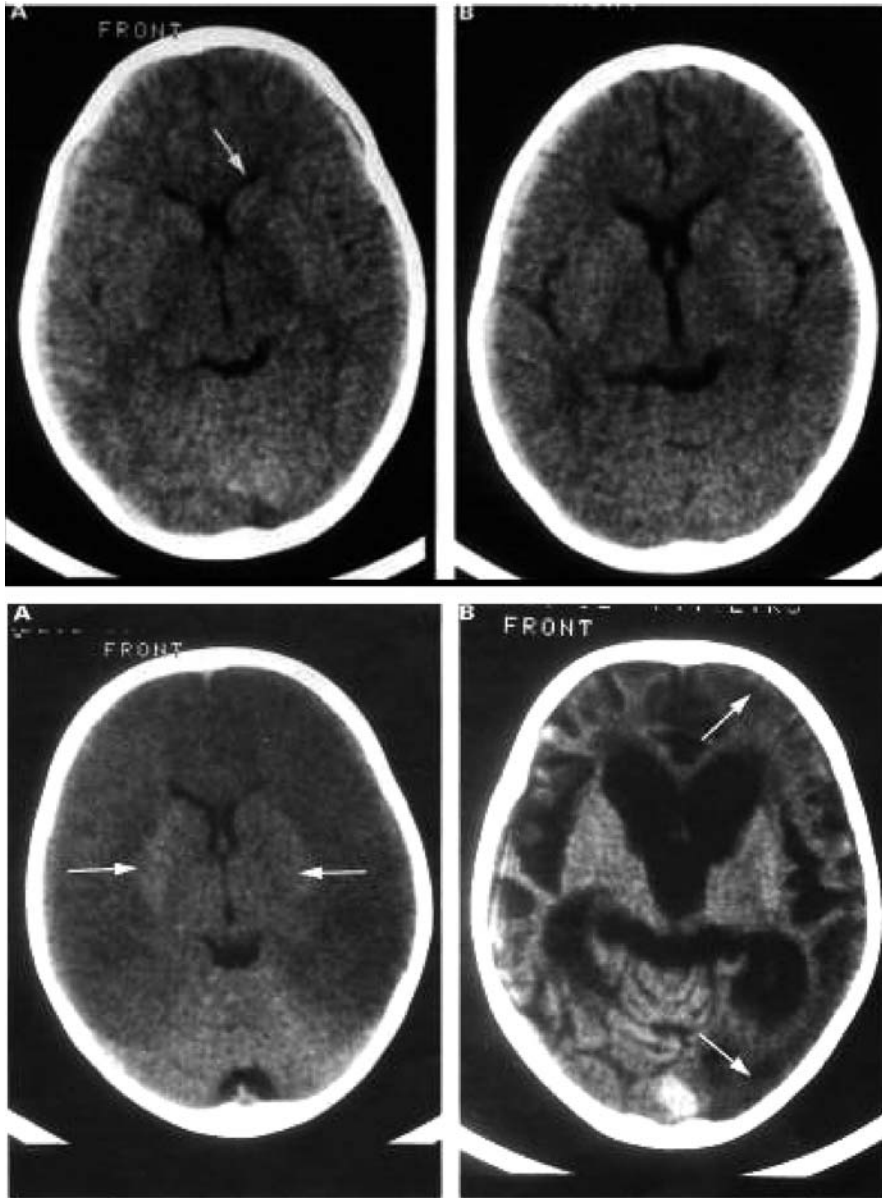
A CT scan of the brain in a Kenyan child with cerebral malaria showing (A) swelling of the brain with compressed ventricles (arrow) and loss of sulci and (B) Resolution of the brain swelling
